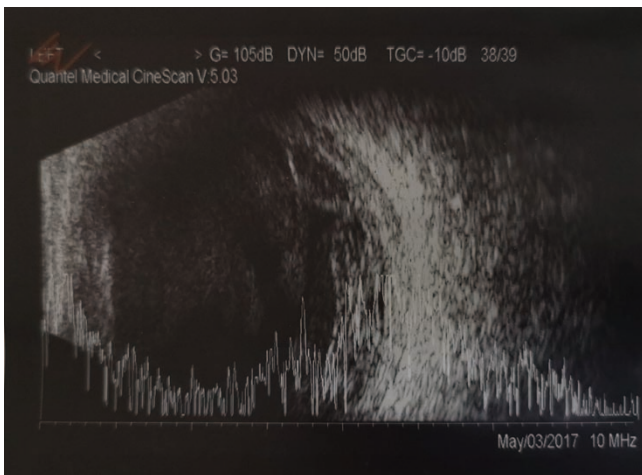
Case 2: Ultrasound B-Scan showed severe vitritis with thickened sclera on presentation.
